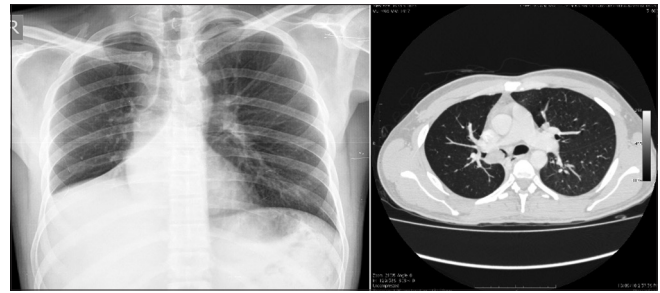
Chest X-ray shows the right lower lobe collapse, and computed tomography section shows mass in right main bronchus
